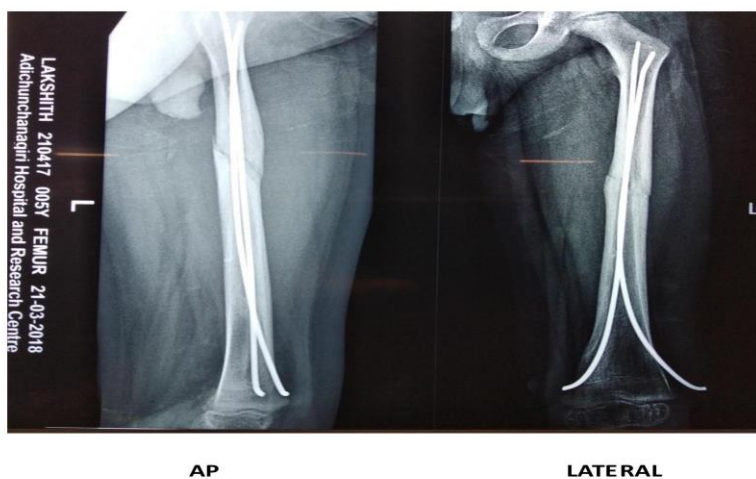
Case 1 - Post-operative 4th week follow-up radiographs (AP and lateral views) showing well-positioned TENS with early callus formation at the fracture site.
